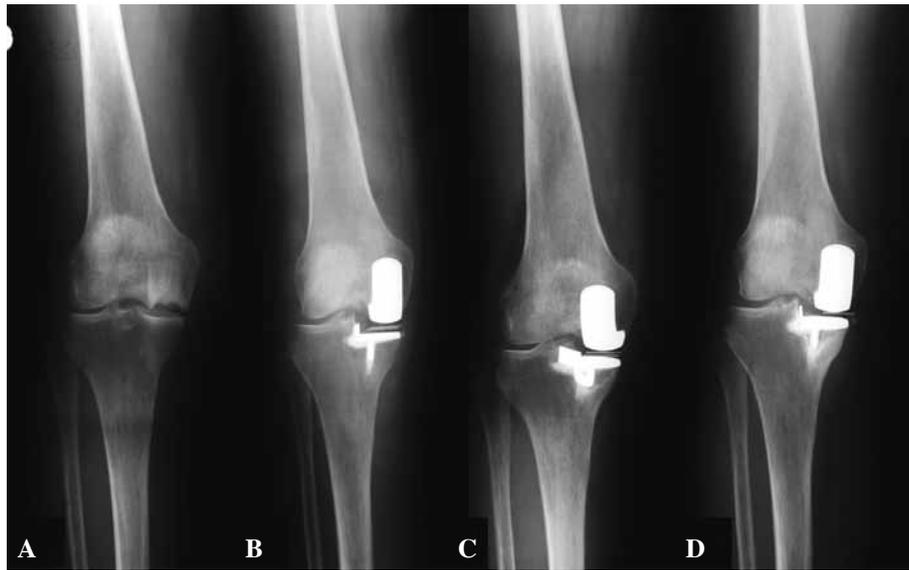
Radiographs of a right knee. A : Preoperative anteroposterior (AP) view showing osteonecrosis of the medial femoral condyle, B : Postoperative AP view following Oxford II UKA, C : AP view at 6 months postoperative, D : AP view at one year postoperative showing signs of osteolysis below the tibial plateau (aseptic loosening).
